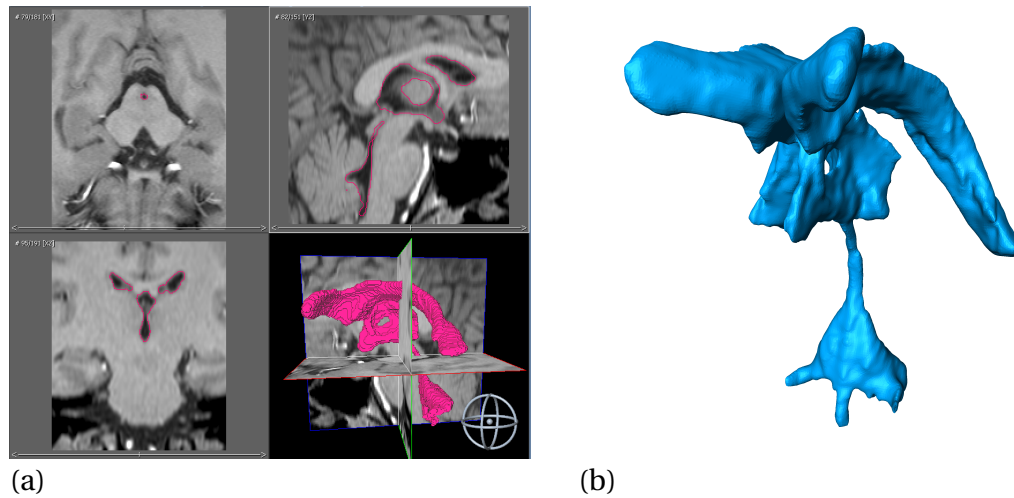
The MRI segmentation process in Amira is completed by (a) importing the raw data and creating ‘labels’ for the features of interest – in this case the ventricular system. This can be completed automatically, or for more detail, the feature can be highlighted in each slice, slowly building up a three-dimensional volume. (b) For this labelled volume, a surface is created and optional smoothing algorithms can be executed to create the final surface of the ventricular system.
